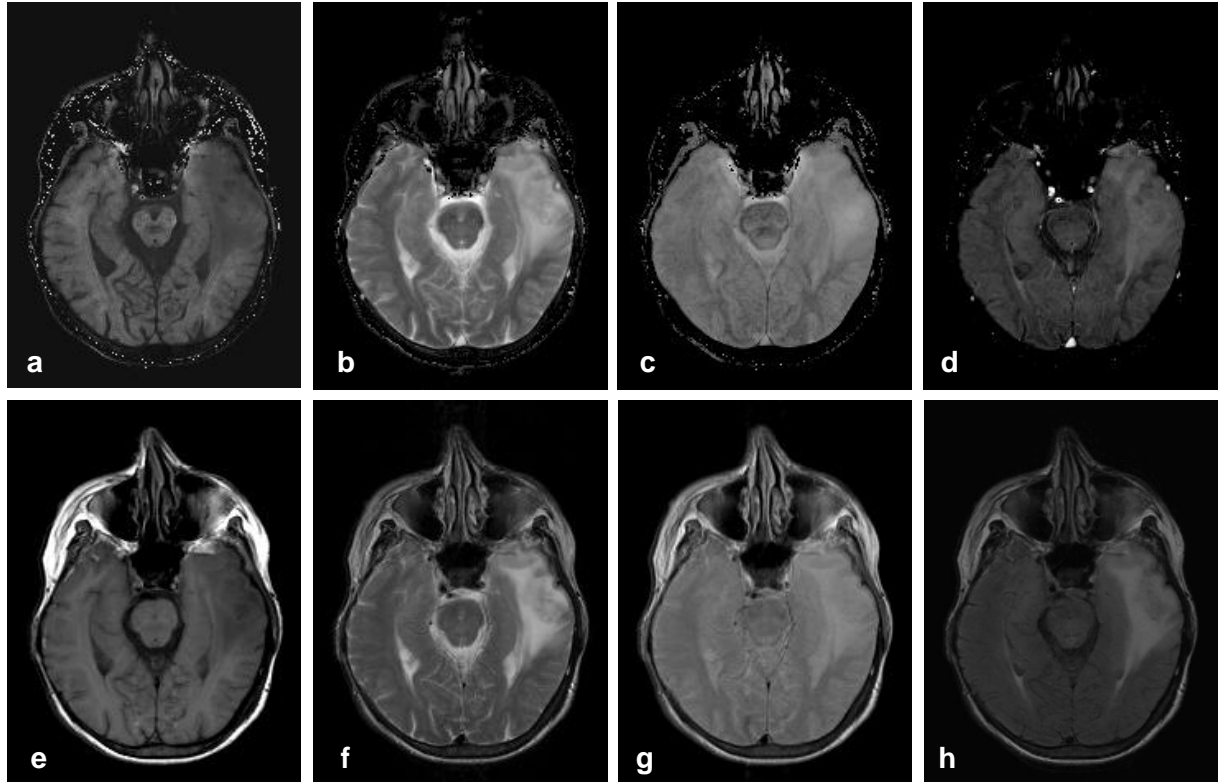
Patient (male, 73 years) with glioblastoma; Synth. images: (a) T_1 -w. with $TR/TE = 500/14$ ms, (b) T_2 -w. with $TR/TE = 4000/98$ ms, (c) spin density-w. with $TR/TE = 4000/16$ ms, and (d) FLAIR with $TR/TI/TE = 6500/2200/105$ ms; (e-h) corresponding acquired images from separate sequences.
